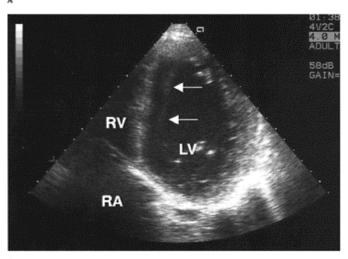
Modified apical four-chamber view. Smoke sign (spontaneous echo contrast), indicating stagnant blood flow in the left ventricular cavity after large anterior myocardial infarction. Note the moving smoke-like echoes (arrows) in the left ventricular cavity in different frames (A and B). LV: left ventricle; RA: right atrium; RV: right ventricle.
